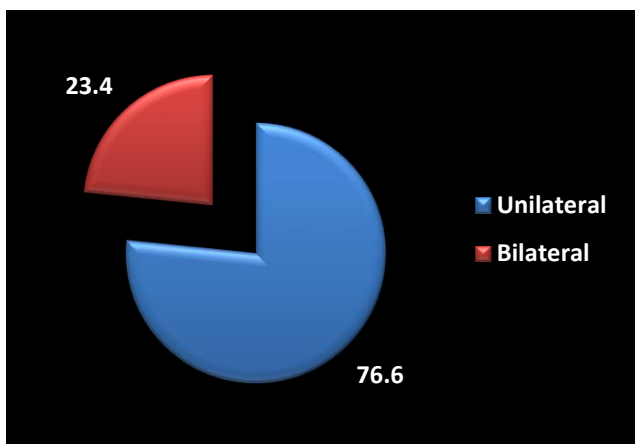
Sinus side involvement in CT-scan of nasal polyps
